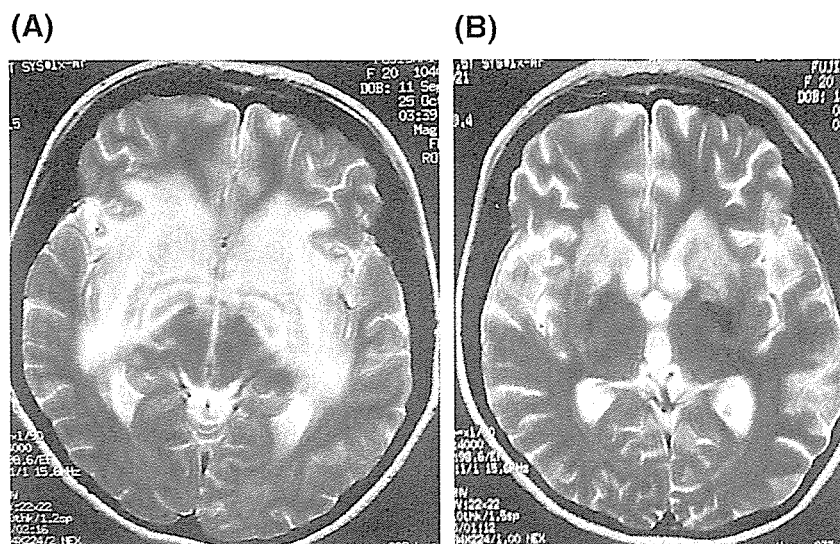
Sagittal T2-weighted MRI. (A) Day 0, (B) Day 130.
